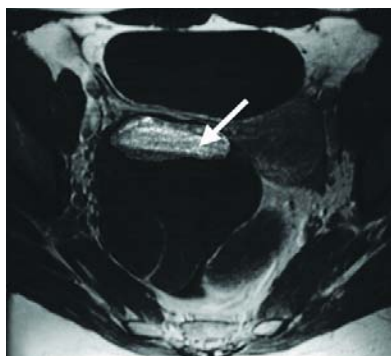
Mature cystic teratoma. T1-weighted pre-contrast magnetic resonance image. A fat-fluid level is seen (arrow).
